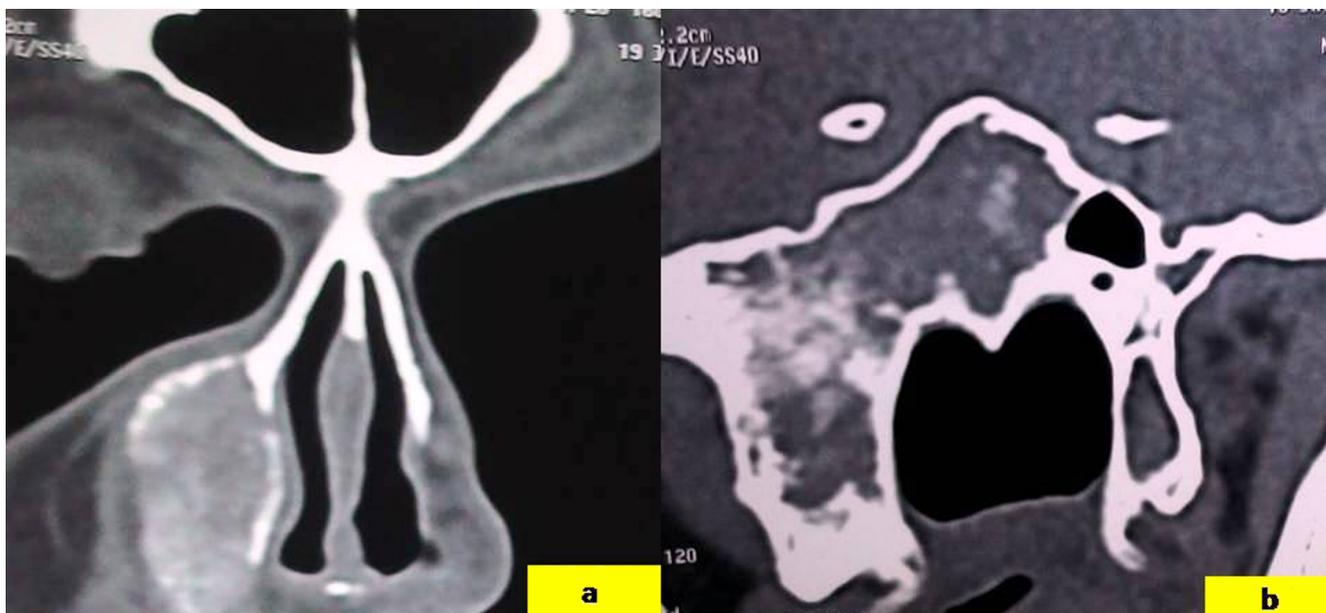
(a & b) CT scan of paranasal sinus showing tumor of heterogeneous mass involving frontal process of maxilla, maxillary sinus (a), sphenoid sinus, pterygoid plates (b)
